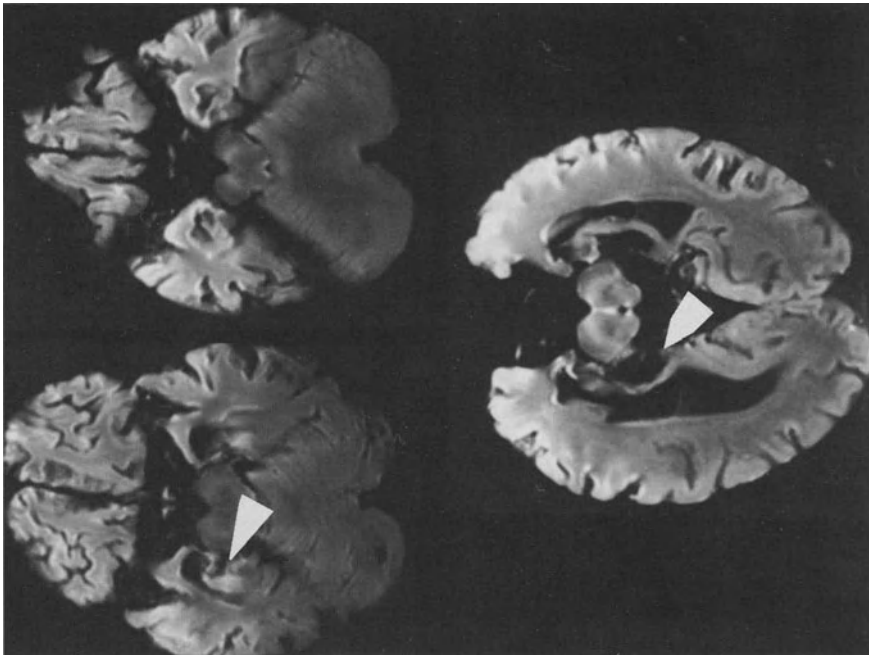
Transaxial postmortem MRI scans depicting the hippocampal region. The conventional cantho-meatal plane study is shown in the *top two images* and the negative angulation from the same patient *below*. The *arrows* point to the region of the choroidal-hippocampal fissure complex
